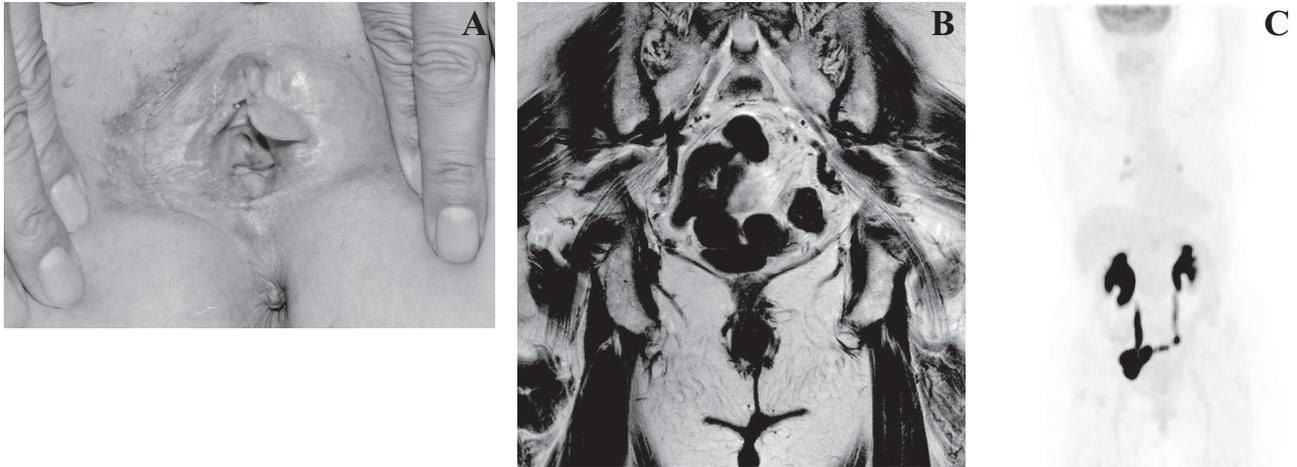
a) Preoperative photograph of the lesion. b) Pelvic magnetic resonance image showing no evidence of local recurrence or metastasis. c) Positron emission tomography-computed tomography showing no abnormal hypermetabolic lesion indicative of local metastasis.
